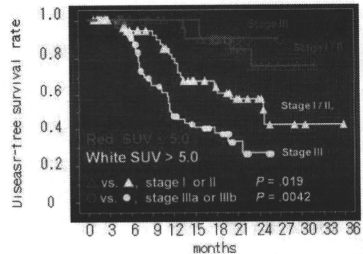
FDG-PET を用いた非小細胞癌における病期別に検討。早期群 (Stage I/II, n=90) と進行群 (Stage III, n=72) での SUV 値 (cut-off, 5.0) を用いて比較。早期群、進行群いずれにおいても SUV が 5 以下の群で良好な腫瘍制御率を示す。(文献 1 より引用)
